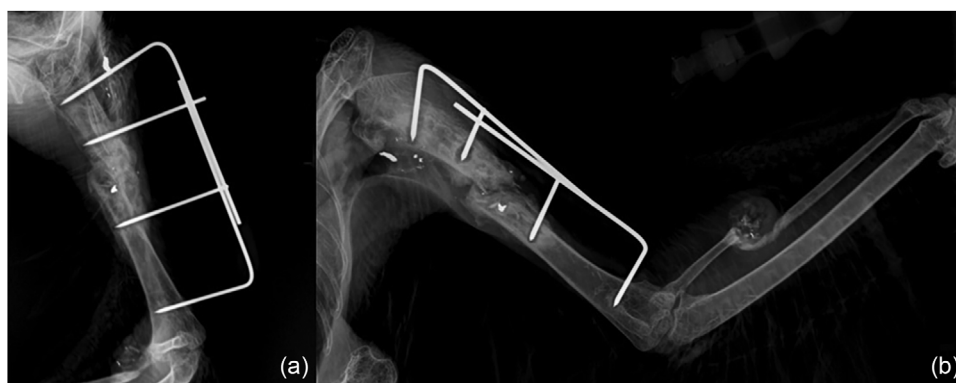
Radiographs of the left thoracic limb in caudocranial (a) and mediolateral (b) views, 4 weeks postoperatively. Observe external callus formation and a visible fracture line in the humerus, and external callus bridging the two fracture ends in the radius.
